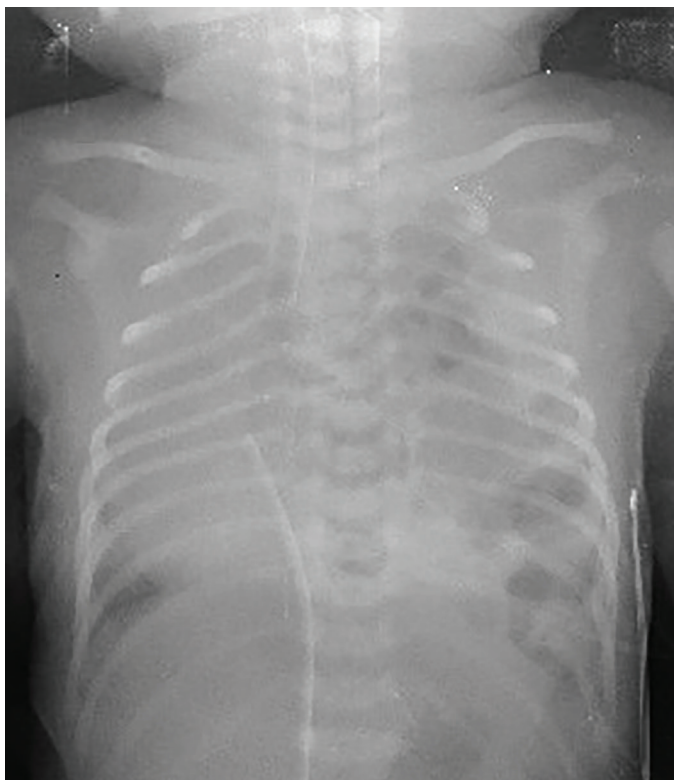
Chest X-ray which demonstrates congenital diaphragmatic hernia on the left side. Right hemithorax looks radiopaque possibly due to mediastinal shift
